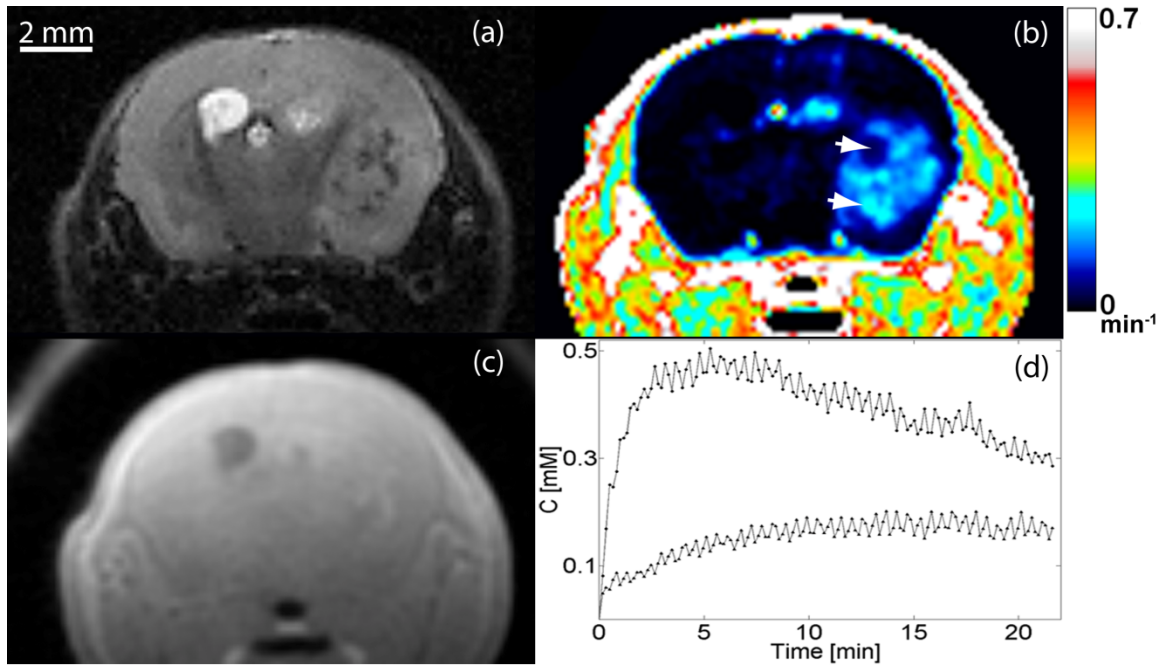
Representative MR images of cortical glioma. Tumors appear hyperintense on (a) $T2$ -weighted and (c) hypo/iso-intense on $T1$ -weighted MRI. (b) K^{trans} map at same axial location. (d) Concentration of the contrast agent as a function of time at two pixels (arrowheads in panel (b)) with distinct permeability parameters.
